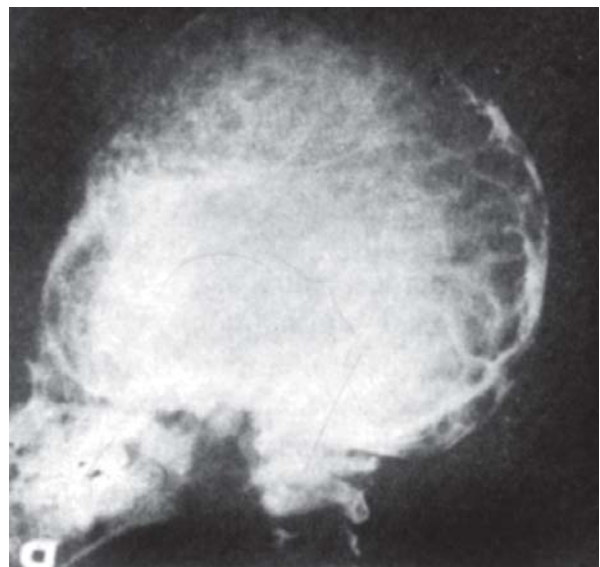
Skull X-ray in craniostenosis. Note the oxycephalic skull with silver-beaten appearance
